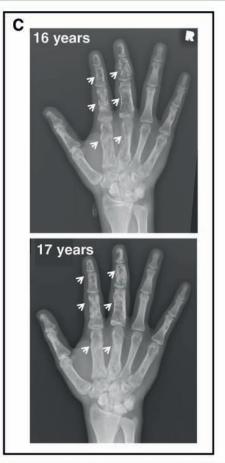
Changes in mineral metabolism and radiographic findings in CSHS105 following treatment with phosphate and calcitriol. a. Fasting biochemistries, measured when off medication for at least 48 h, had normalized by age 17.5 years. Initially FGF23 was measured using a "C-terminal" assay that detects both C-terminal fragments and intact molecule ((star) Immutopics, San Clemente, CA); subsequently, FGF23
